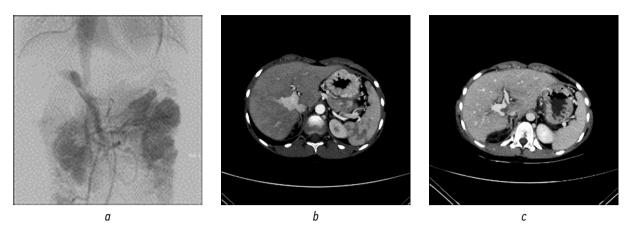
Case No. 6. The results of X-ray examination of patient: a — angiography. Examination before surgery. A congenital portosystemic shunt is visualized. There is marked hypoplasia of the intrahepatic branches of the portal vein; b — computed tomography. Examination before surgery. The portocaval junction is visualized; c — computed tomography after surgery. Significant improvement in hepatic blood flow. There are no signs of a functioning congenital portosystemic shunt
